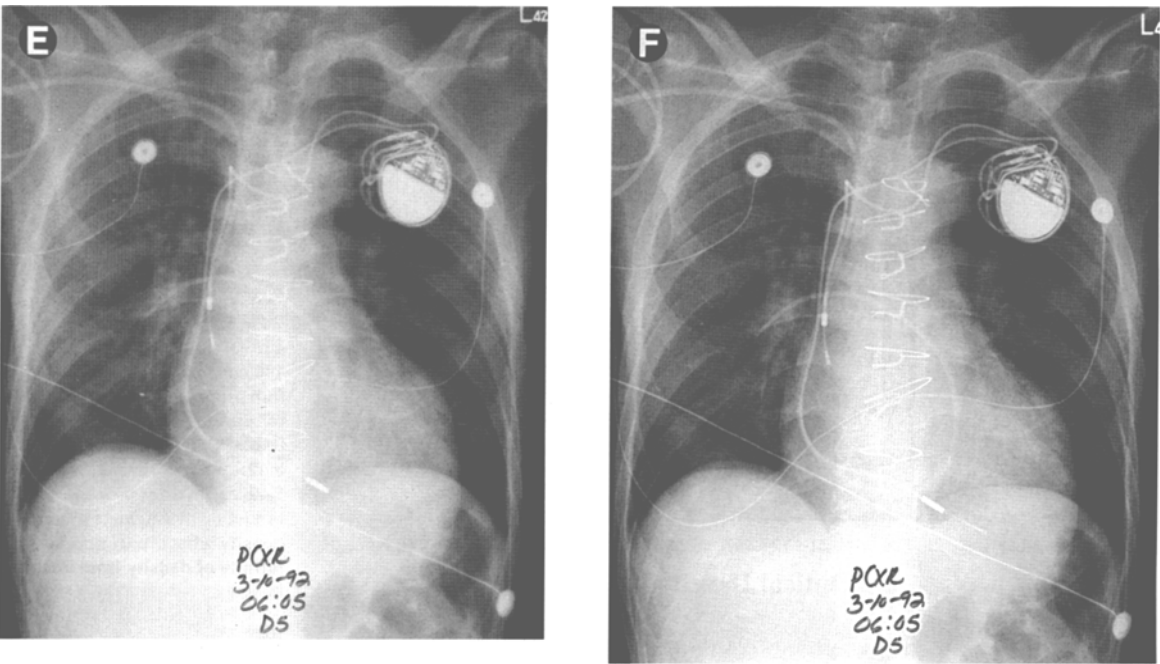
A series of digitally duplicated portable chest radiographs before processing (A, C, E) and the corresponding digitally processed images (B, D, F). The original radiographs (A, C, E) were determined by the density-correction program to have exposure levels of 0.8, 2.8, and 1.0 times the proper exposure, respectively.
